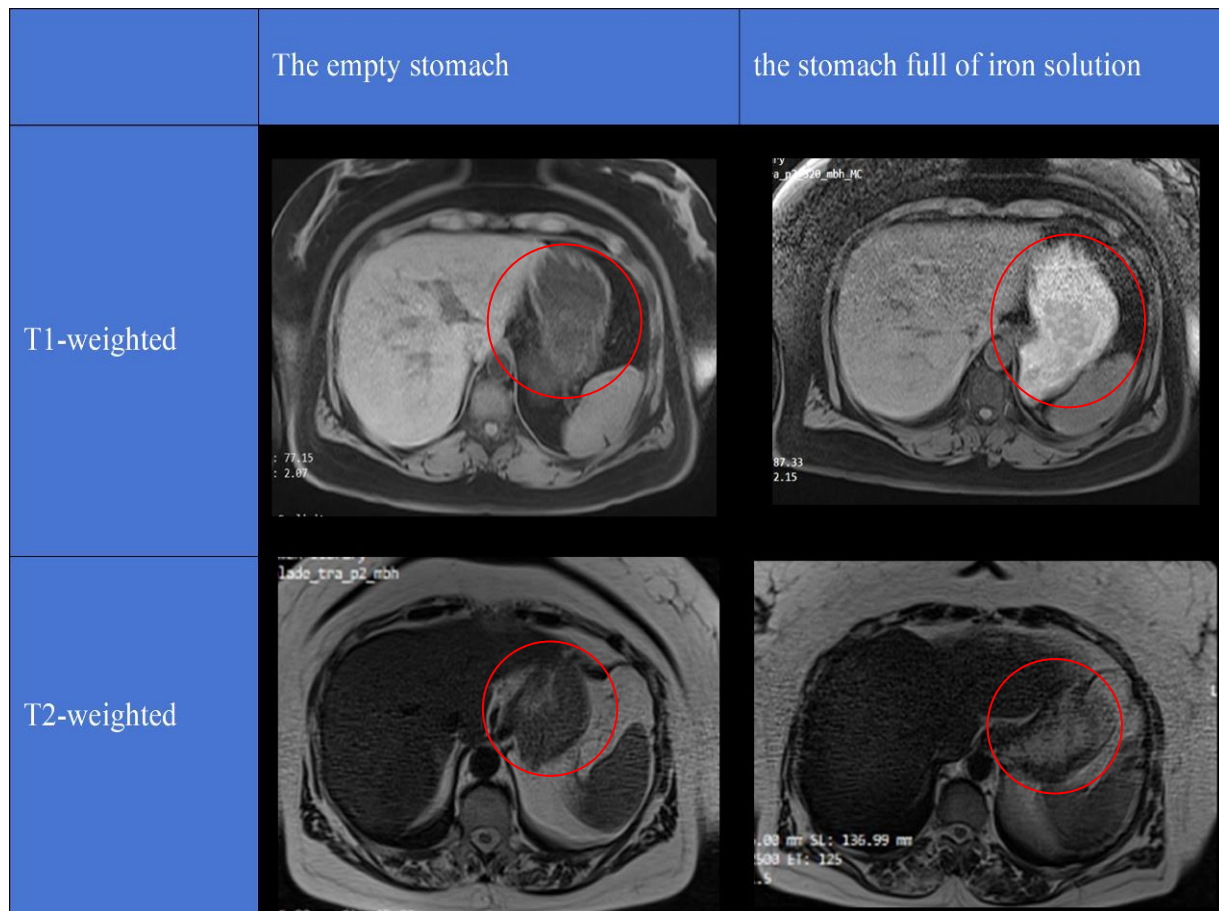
Transverse abdominal *MRI* for an empty stomach and a stomach full of iron solution
